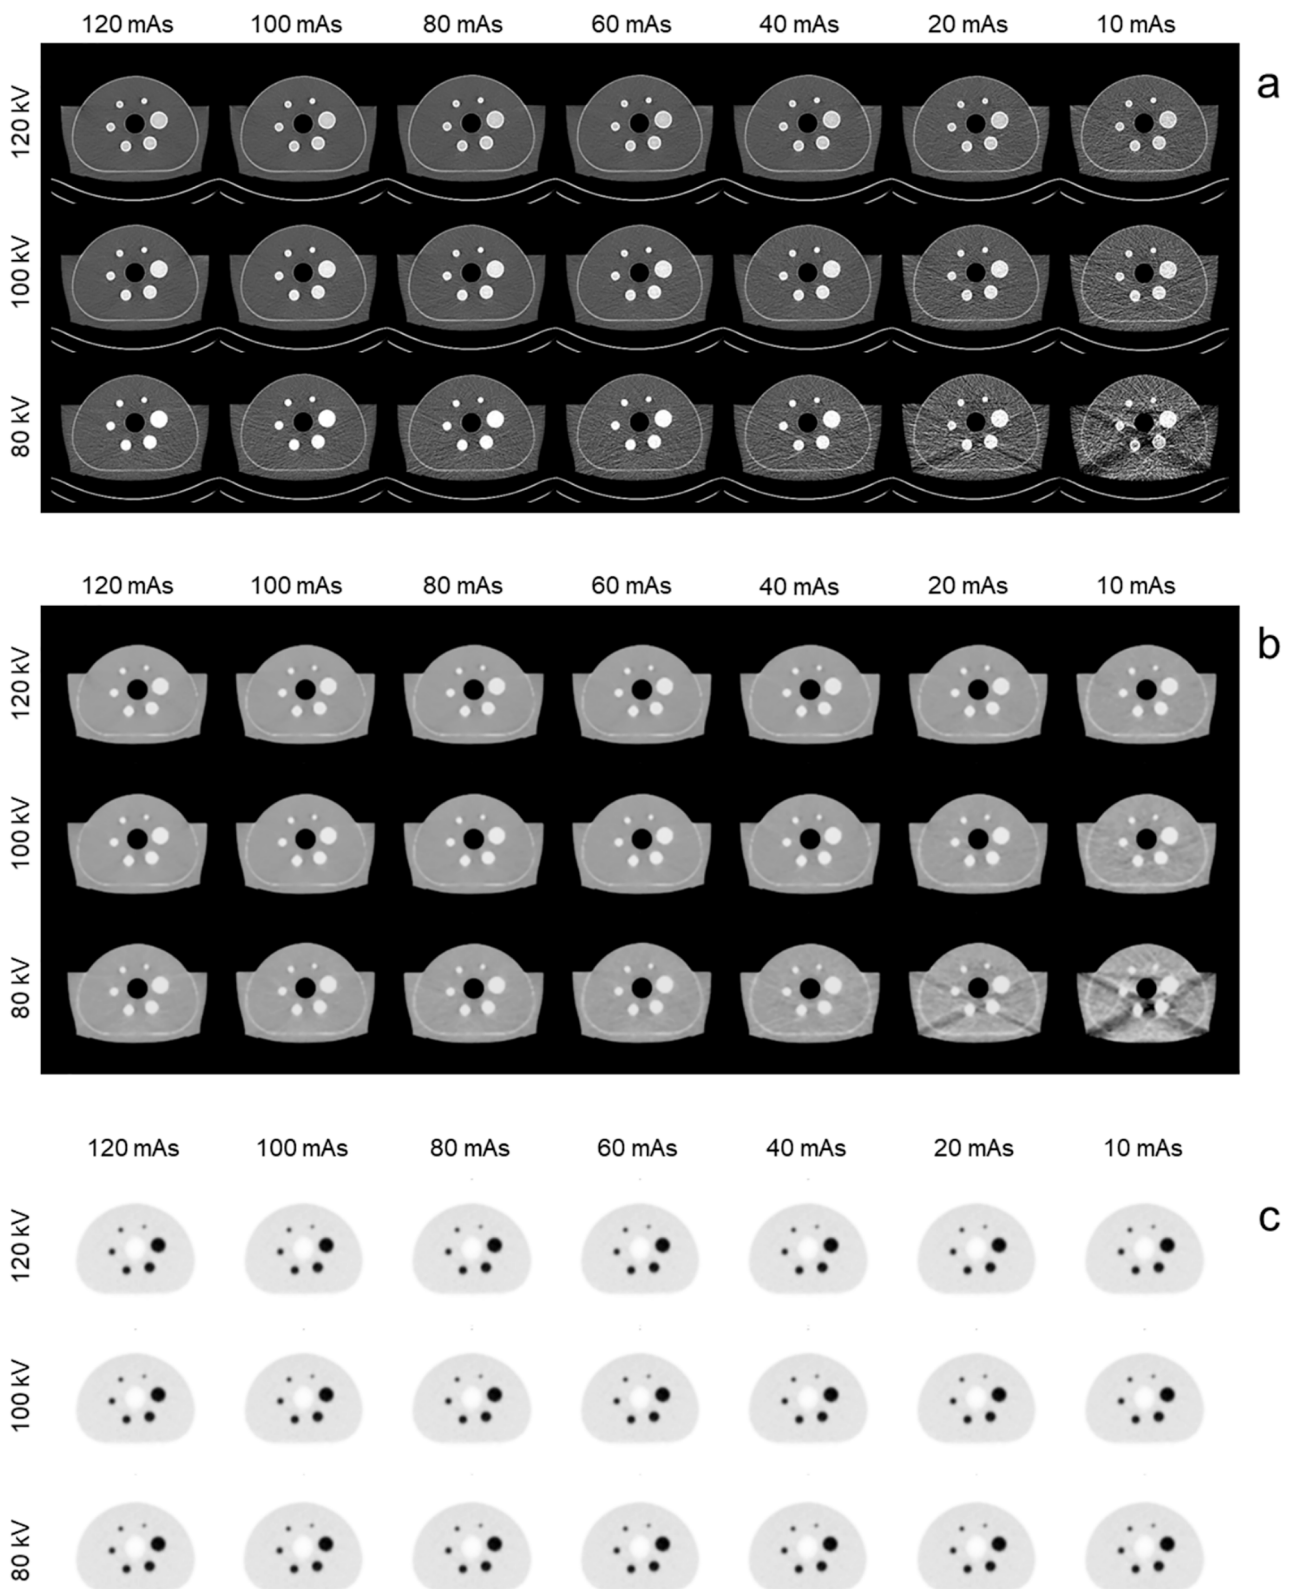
CT (a), μ -map (b) and PET (c) images obtained with the 21 different CT acquisition parameters.
